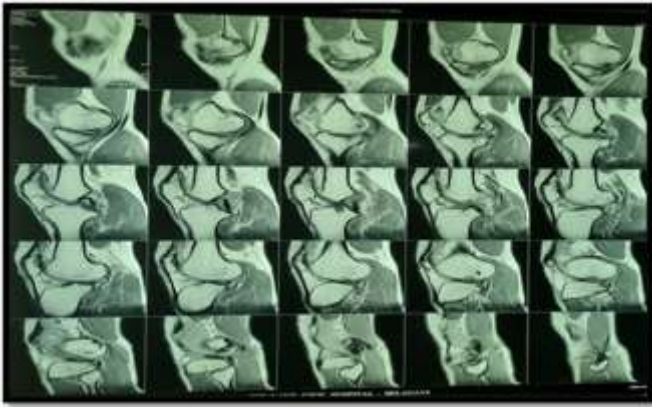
MRI of anterior cruciate ligament injury
